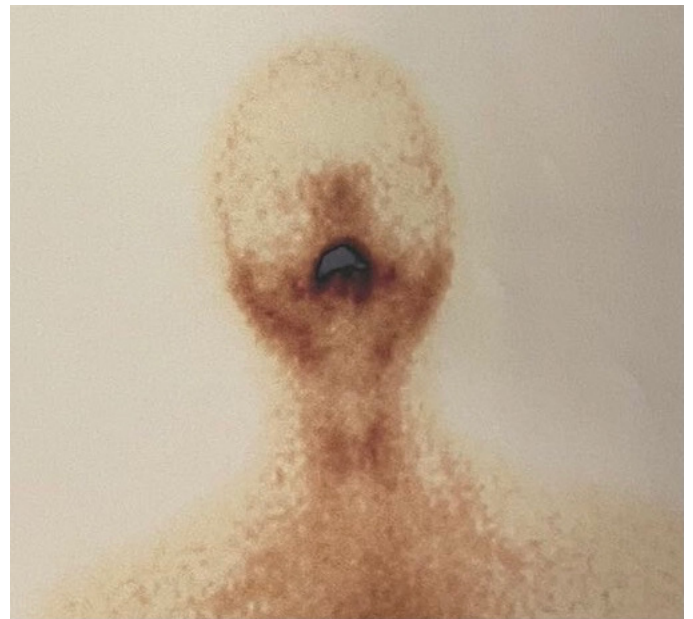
Reduction of radioiodine uptake in SAT scintigraphy (patient number 7 from Table 1)
